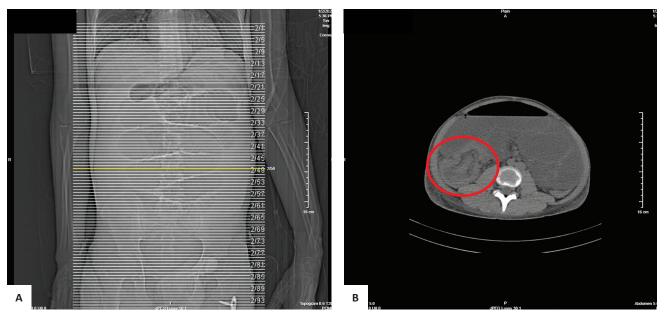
(A) CT Whole Abdomen with IV contrast (Coronal Plane) showing a bowel-within-bowel configuration; (B) CT Whole Abdomen with IV Contrast (Transverse Plane) showing a bowel-within-bowel configuration (red circle).
